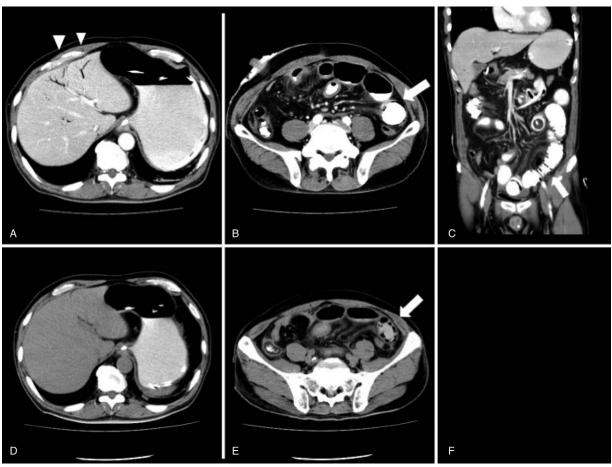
CT scan findings. (A–C) CT scan revealed portal vain gas (triangles) and pneumatosis cystoides intestinalis (arrow) but did not accompany intestinal blood flow disturbance. (D, E) CT scan after 9h revealed portal vein gas had disappeared, however, pneumatosis cystoides intestinalis remained (arrow).
